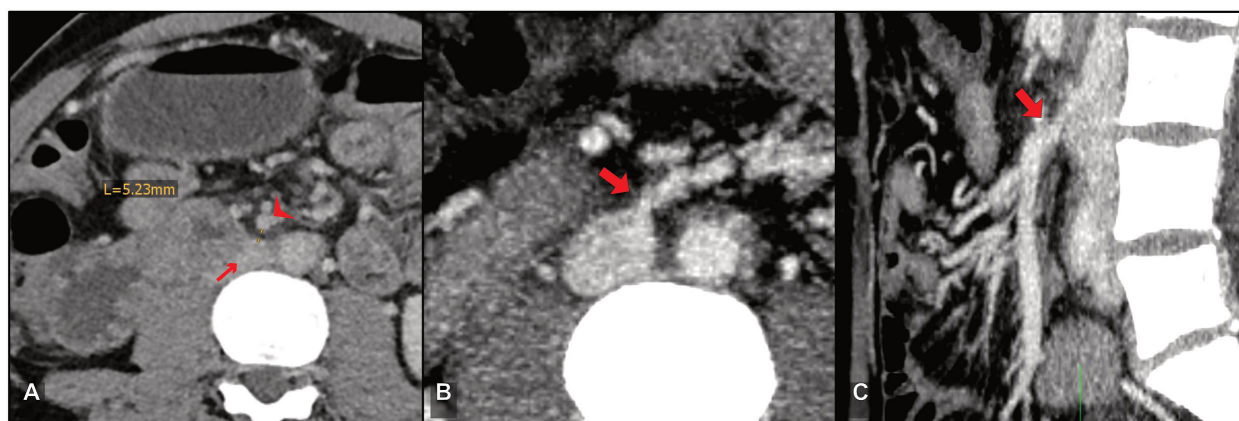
49-year-old male patient with liver cirrhosis, extrahepatic portal vein thrombosis and advanced symptoms – PSS procedure: mesocaval; A: Preoperative CT; B: Postoperative CT, axial MIP
